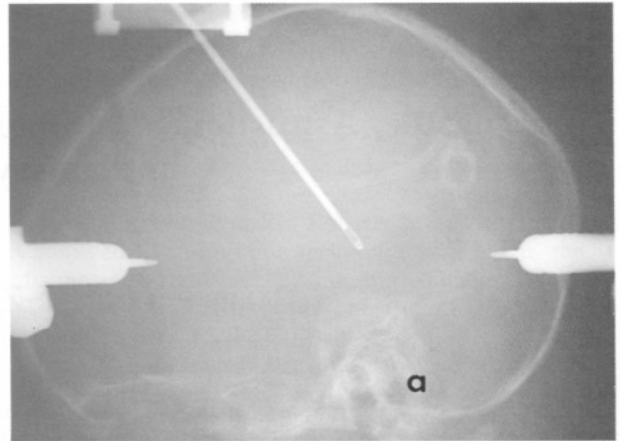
a, Lateral skull X-rays showing the trajectory of the biopsy needle; b, T1-weighted sagittal MRI scan showing well demarcated, cortico-subcortical parietal tumor. Deep tumor still remaining, note the linear hypointensity between two lesions on the same trajectory as the biopsy needle.
